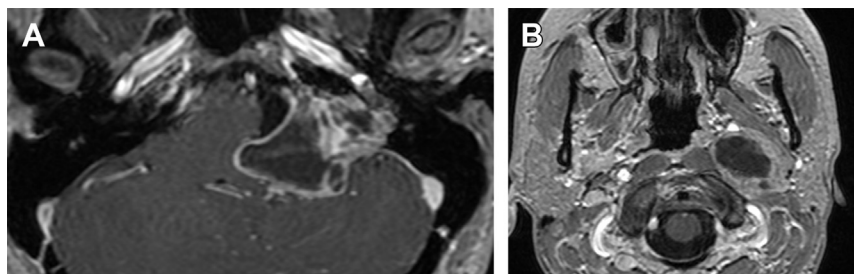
Vagus schwannoma. Postcontrast axial MRI in the (A) lateral medullary cistern and (B) upper neck demonstrate a heterogeneously enhancing mass with imaging characteristics similar to a vestibular schwannoma, but a more inferior location and involvement of the jugular bulb. (B) Extension into the carotid sheath is common for lesions that arise in the jugular bulb.
